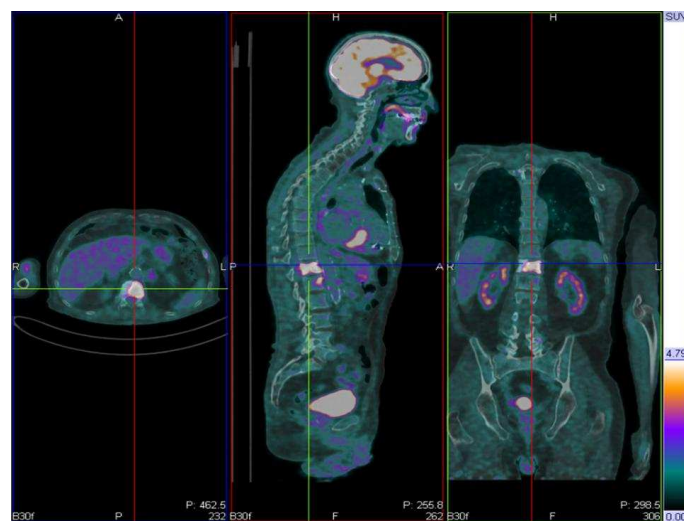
transaxial, sagittal and coronal 18F-FDG PET/CT images showing an intense uptake in D12
